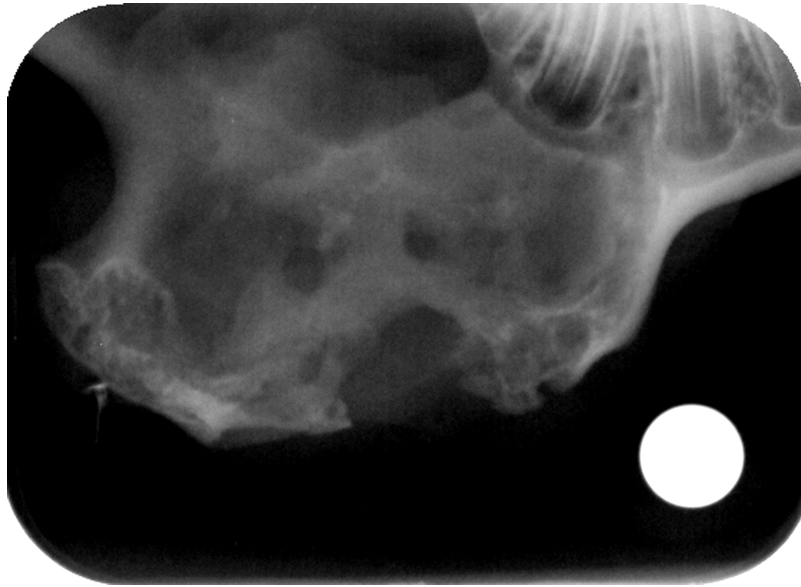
Digital radiograph from the right side (membrane + BAG) at 24 weeks. Mineralization of the defect is not yet complete.
